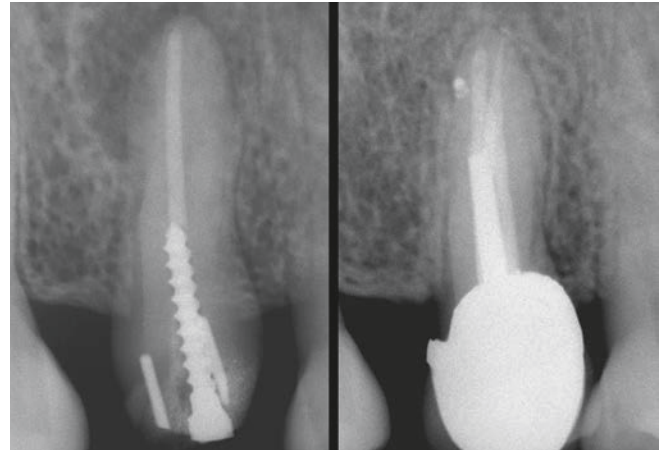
Left: A radiograph of an endodontically failing maxillary bicuspid. Note pins, a post, and that the obturation material is not centered within the root. Right: A 10-year recall radiograph shows excellent osseous repair, the importance of 3D endodontics, and a well-designed restorative.
